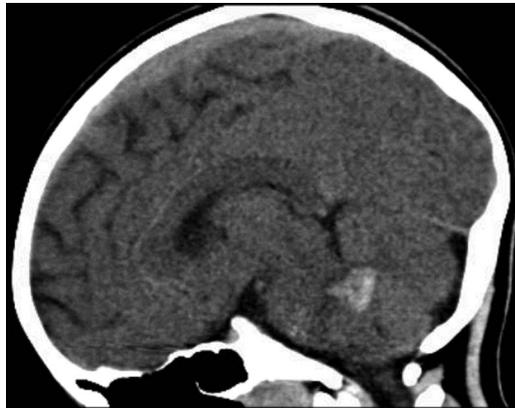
Sagittal CT image demonstrating hyperdense haemorrhagic lesion in the fourth ventricle.
